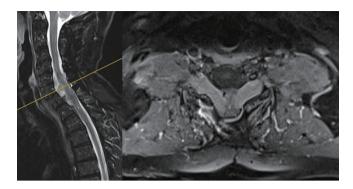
Postoperative magnetic resonance imaging: persistent radicular hypertrophy without myelopathy signs.
